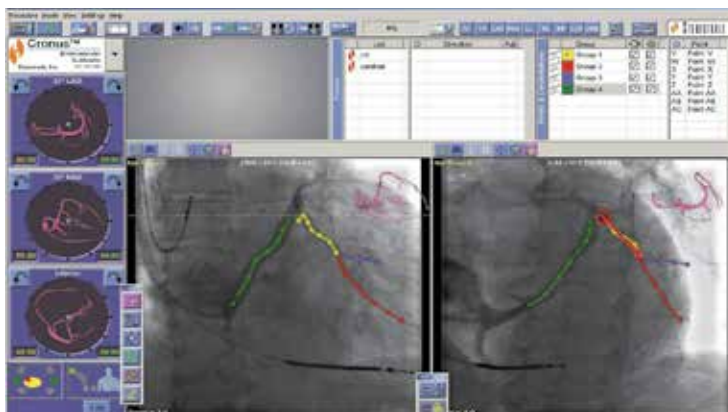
Navigant screenshot. Two x-ray images have been transferred to the navigation software and tributaries of the CS have been marked with colors. The red arrow indicates the direction of the magnetic field vector.
